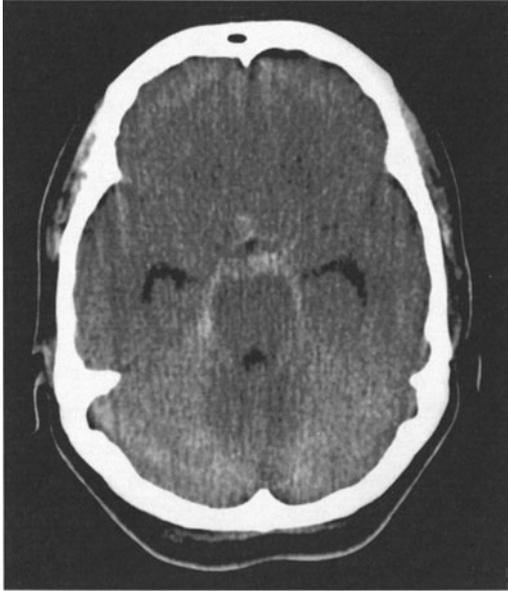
Perimesencephalic, unlocalized subarachnoid hemorrhage. Non enhanced CT scan demonstrating blood in the interpeduncular, prepontine, suprasellar and ambient cisterns. This 46 year old woman experienced the acute onset of "the worst headache in her life" lethargy and nuchal rigidity but had an otherwise normal neurological examination. Two series of angiograms and all hematologic studies were normal. She has done well over the subsequent 7 years.
